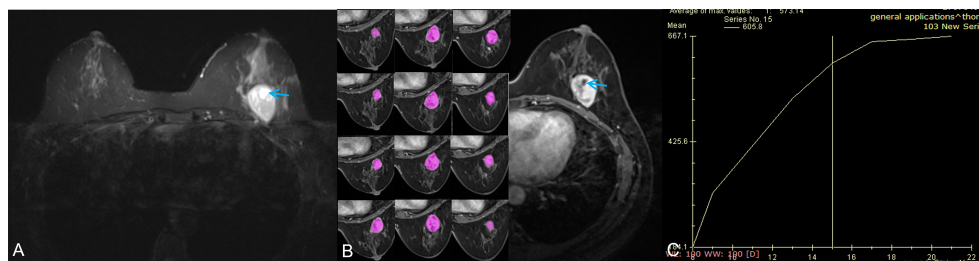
A 42-year-old woman with a benign phyllodes tumor. (A) Axial T2WI showed a heterogeneous mass in the left breast, with a regular wall of cystic area (red arrow). (B) Axial DCE-MRI showed the mass with heterogeneous enhancement and non-enhancement cystic area; the segmentation of VOI was shown on the left series images. (C) The time-intensity curve was type II (plateau pattern).
